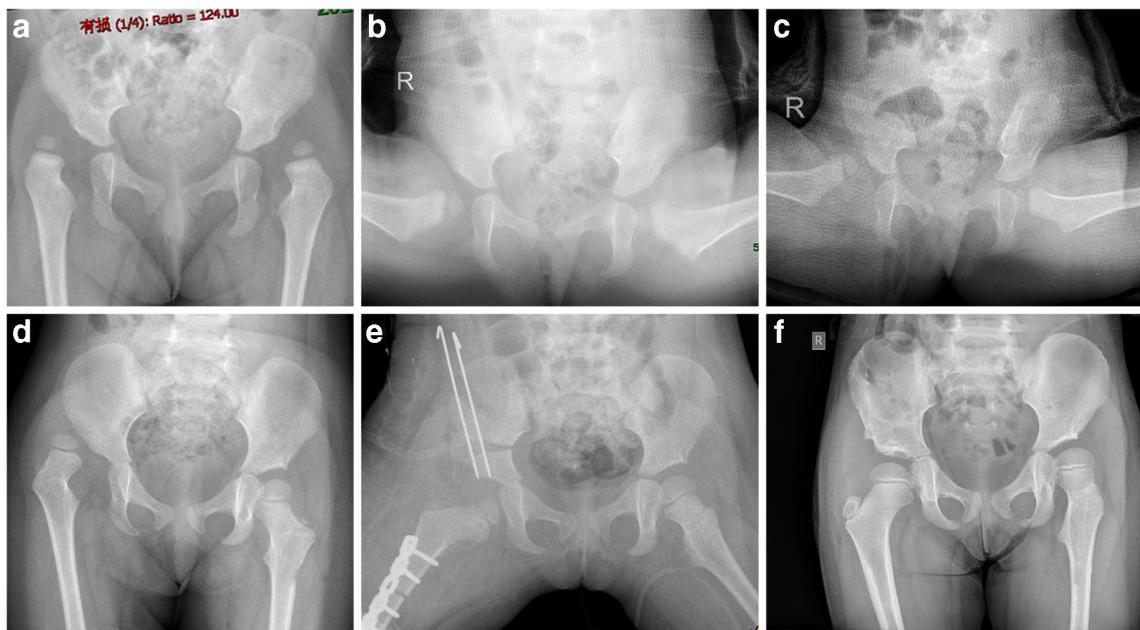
Twenty-six-month-old girl with bilateral DDH treated by closed reduction (a, b). Redislocation occurred and cast removed, the left side achieved good reduction (c, d). Open reduction, pelvic osteotomy, and femoral shortening osteotomy were performed (e); Final radiographic outcome is good (f)
